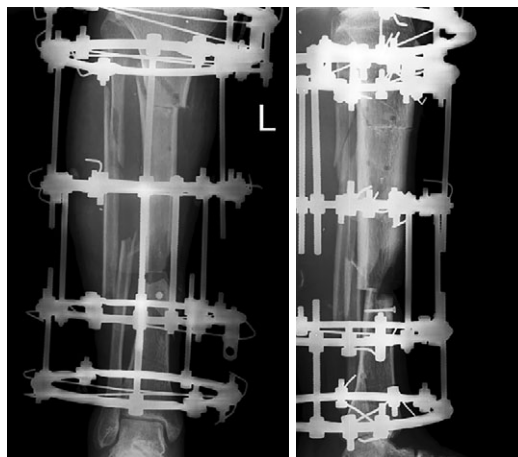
X-rays of the lower leg in frontal and lateral projections after osteotomy of the upper third of the tibia
